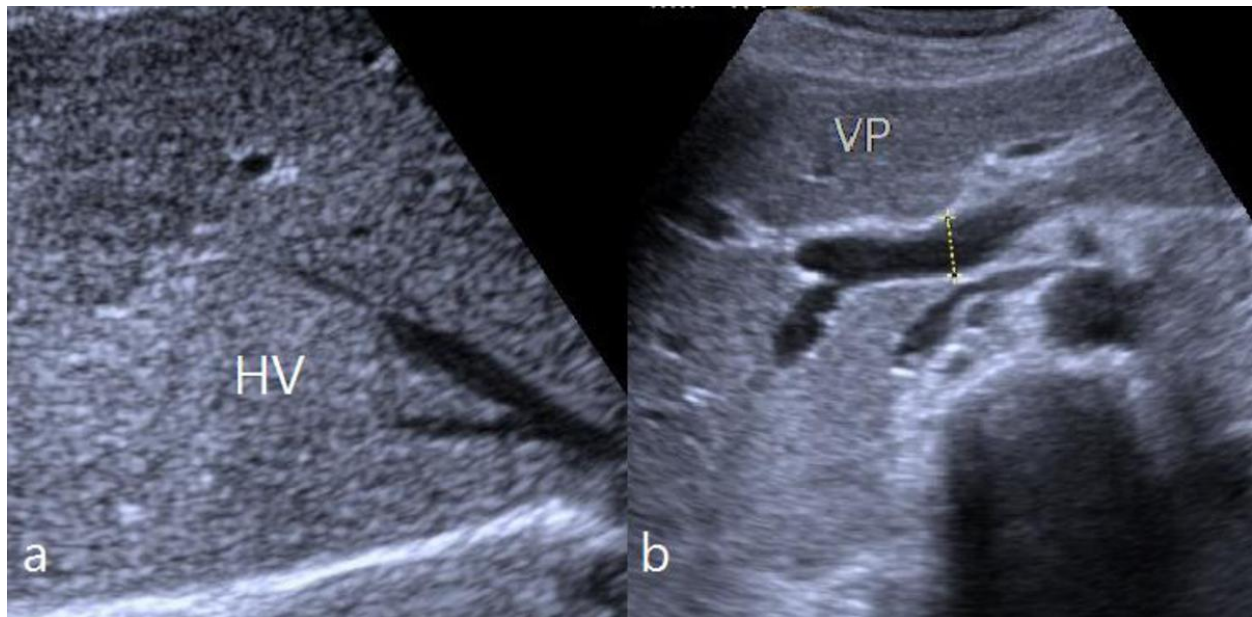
Ultrasound images of normal hepatic veins (a) and portal vein (b) in gray scale (HV - hepatic veins; VP - portal vein).
